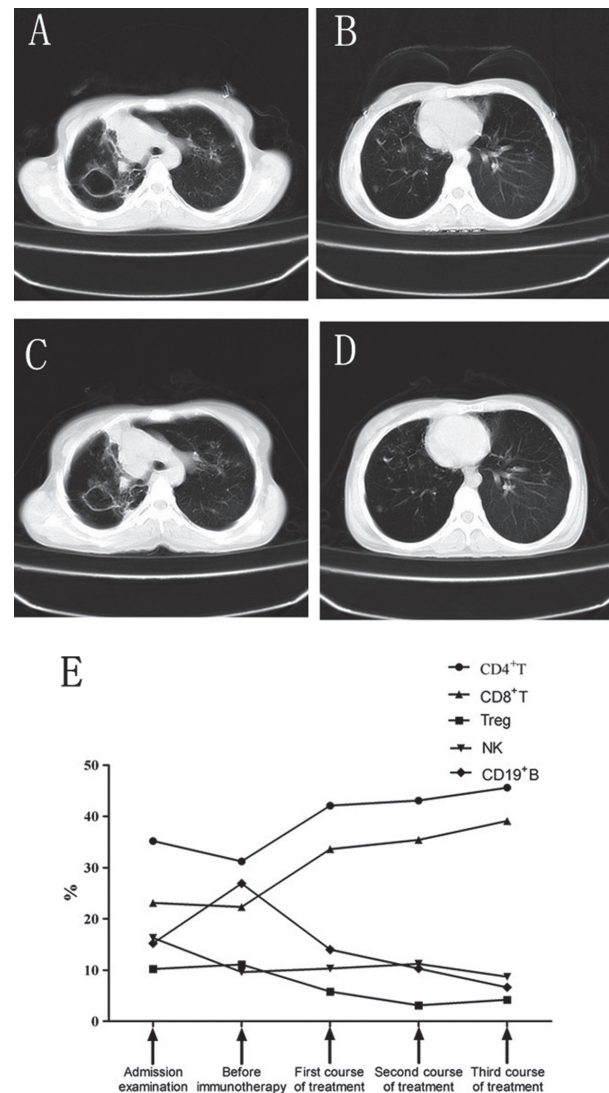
Thoracic CT (A,B,C,D) and the changes of lymphocyte subsets (E). The time points of A and B are the initial examination. The time points C,D are 1 month later after the third course of CIK immunotherapy. Compare with before and after CIK treatment, the pulmonary cavity was shrinking, the patch and nodule in some aspects were absorbed E.
